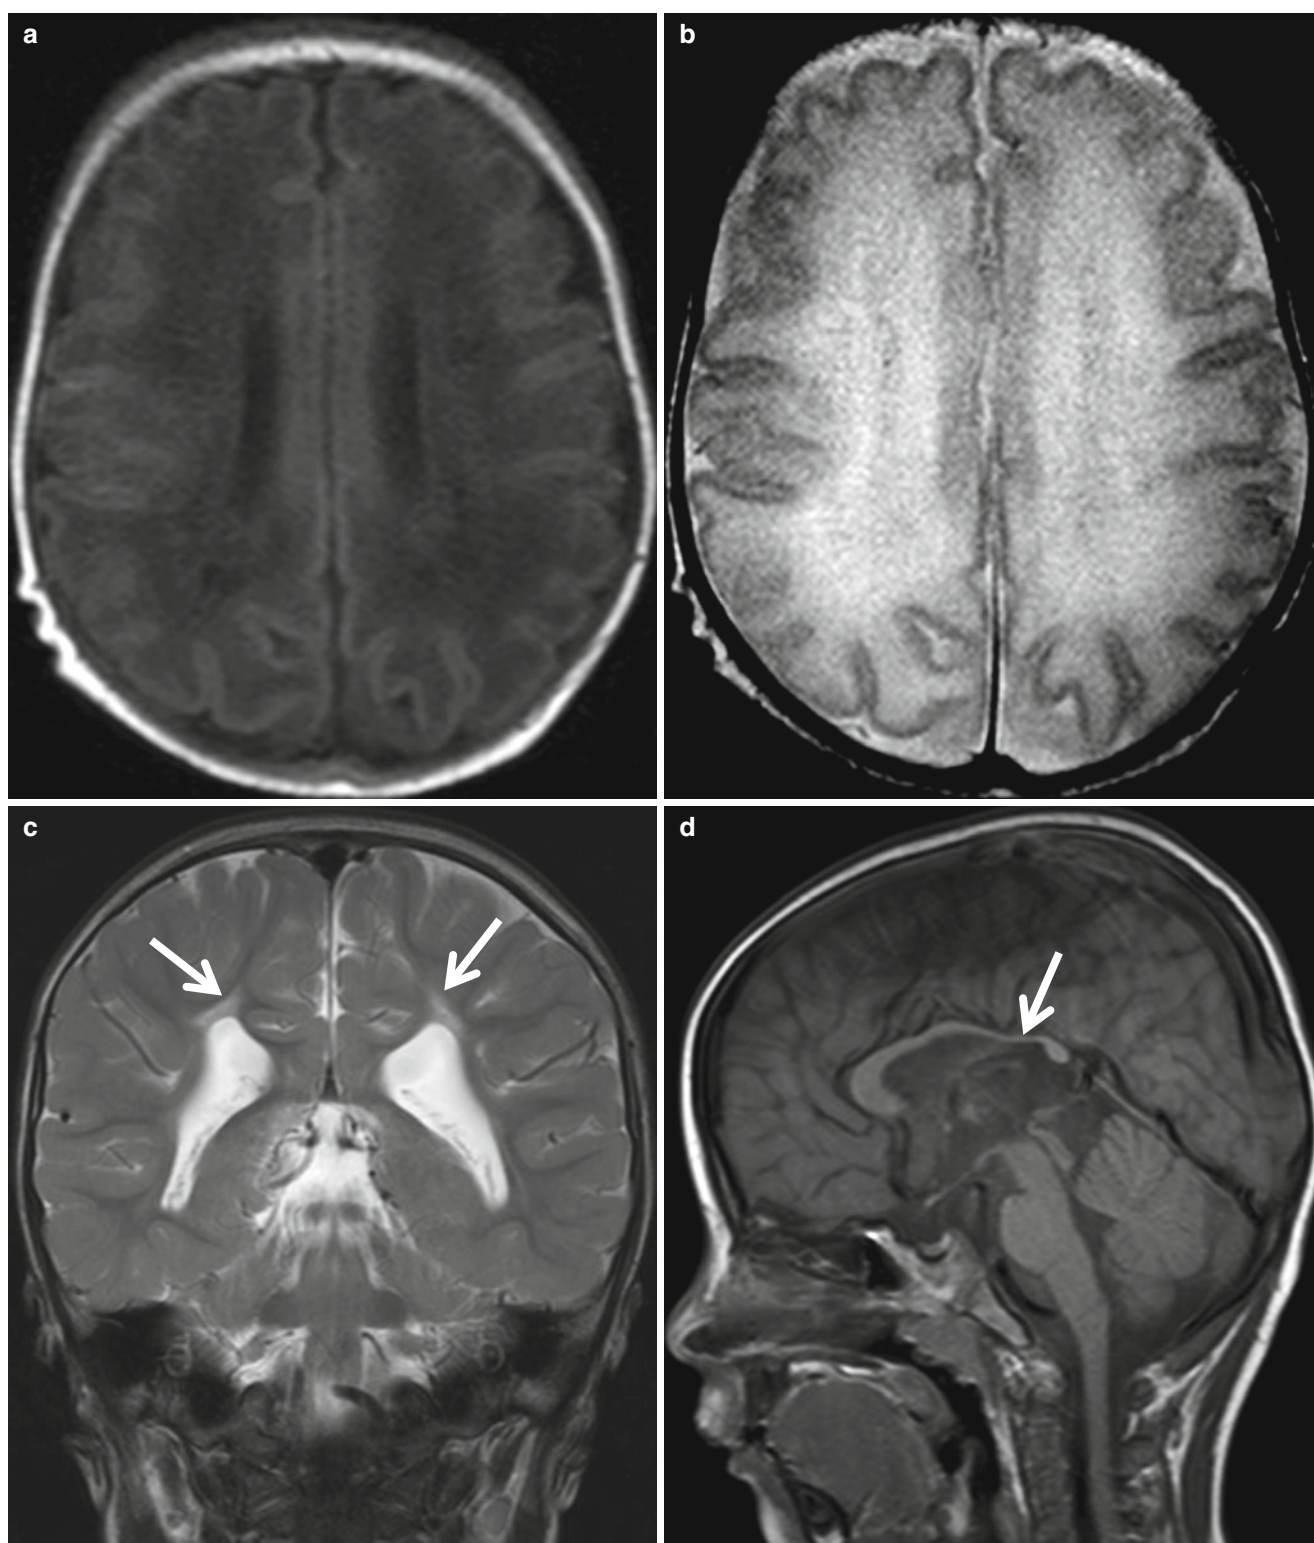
Evolving PVL on MR imaging in preterm neonate. The deep white matter is hypointense on T1-weighted image (a) and hyperintense on T2-weighted image (b) obtained 2 weeks after the birth. Follow-up T2-weighted coronal image obtained 2 years later (c) shows passive enlargement of the lateral ventricles with undulated margins
